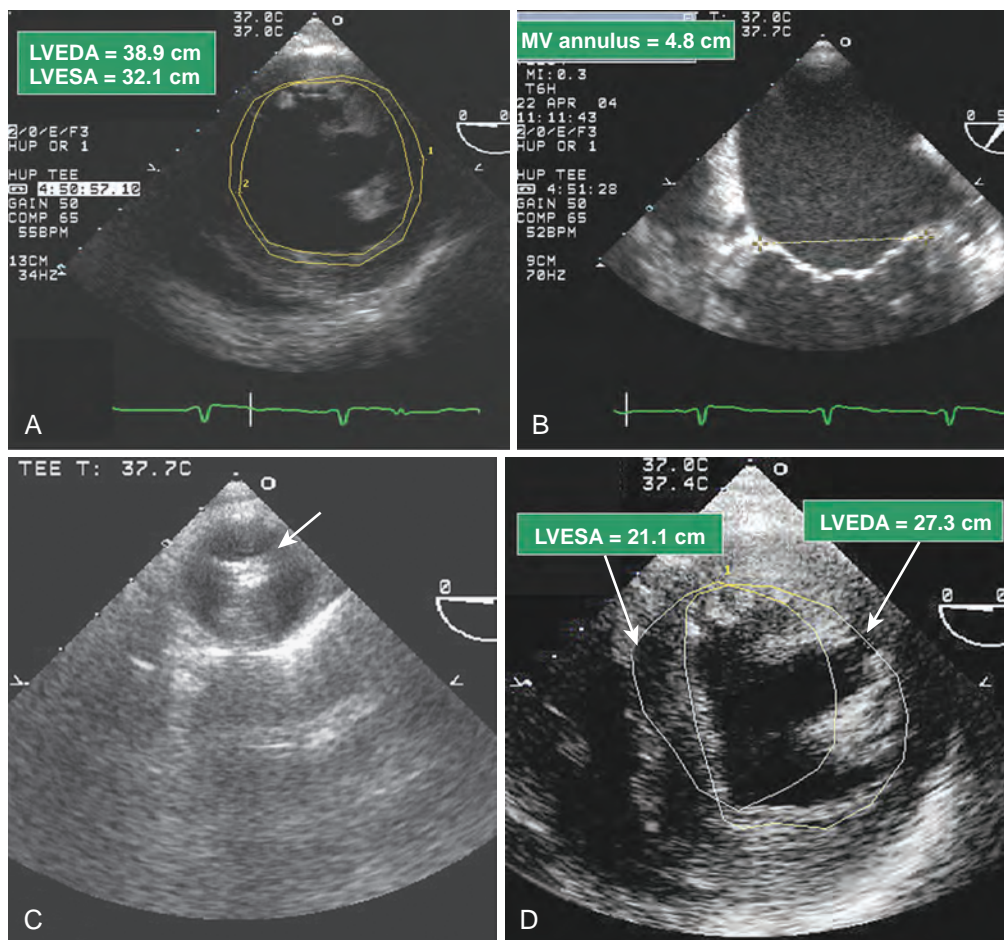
The prebypass transesophageal echocardiography (TEE) examination may have predictive value for postbypass circulatory management. A 63-year-old woman with a medical history of hypertension, congestive heart failure, pulmonary edema, dilated cardiomyopathy, diabetes, and obesity was scheduled for coronary artery bypass grafting (CABG) and mitral valve (MV) repair. The preoperative evaluation documented moderate-to-severe mitral regurgitation (MR) with reversal of systolic pulmonary vein blood flow velocity. (A) The prebypass TEE mid-esophageal four-chamber view showed a markedly dilated left ventricle (LV) and mildly dilated right ventricle (RV) with mildly decreased global dysfunction. The transgastric view was characterized by severe global dysfunction and an LV end-diastolic diameter of 6.6 cm. The fractional area change (FAC) was 17% [$\text{FAC} = (\text{left ventricular end-systolic area [LVESA]} - \text{left ventricular end-diastolic area [LVEDA]}) / \text{LVEDA} \times 100$]. Revascularization alone was unlikely to significantly improve MV function. (B) The mid-esophageal bicommissural view of the MV demonstrated marked dilation of the MV annulus (major axis = 4.8 cm) and tethering of the leaflets below the valve plane that was caused by LV chamber dilation. A femoral arterial line was inserted for monitoring of central aortic pressure and/or possibly placing an intra-aortic balloon pump. The patient underwent a CABG \times 3 and MV annuloplasty for moderate MR. The separation from bypass was difficult, requiring milrinone, epinephrine, vasopressin, and placement of an intra-aortic balloon pump. (C) TEE, which was used to initially confirm the location of the femoral guidewire, was later used to position the balloon pump just downstream to the left subclavian artery. (D) Worsening of RV function that was characterized by increased central venous pressure, new-onset tricuspid regurgitation, and a hypokinetic RV can be appreciated by ventricular septal flattening and dilation of the RV. The LV ejection fraction did not decrease as might be expected; after correcting MR, the FAC improved slightly from 17% to 22% after bypass. Cardiac function continued to improve, and the counterpulsation device was removed without complication on the first day after surgery. The infusions of milrinone and epinephrine were continued for several days.
